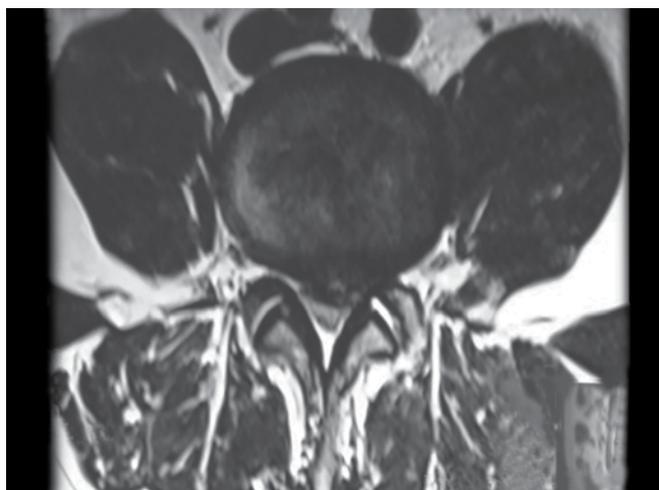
Magnetic resonance imaging T2 axial section showing extruded disk on left
